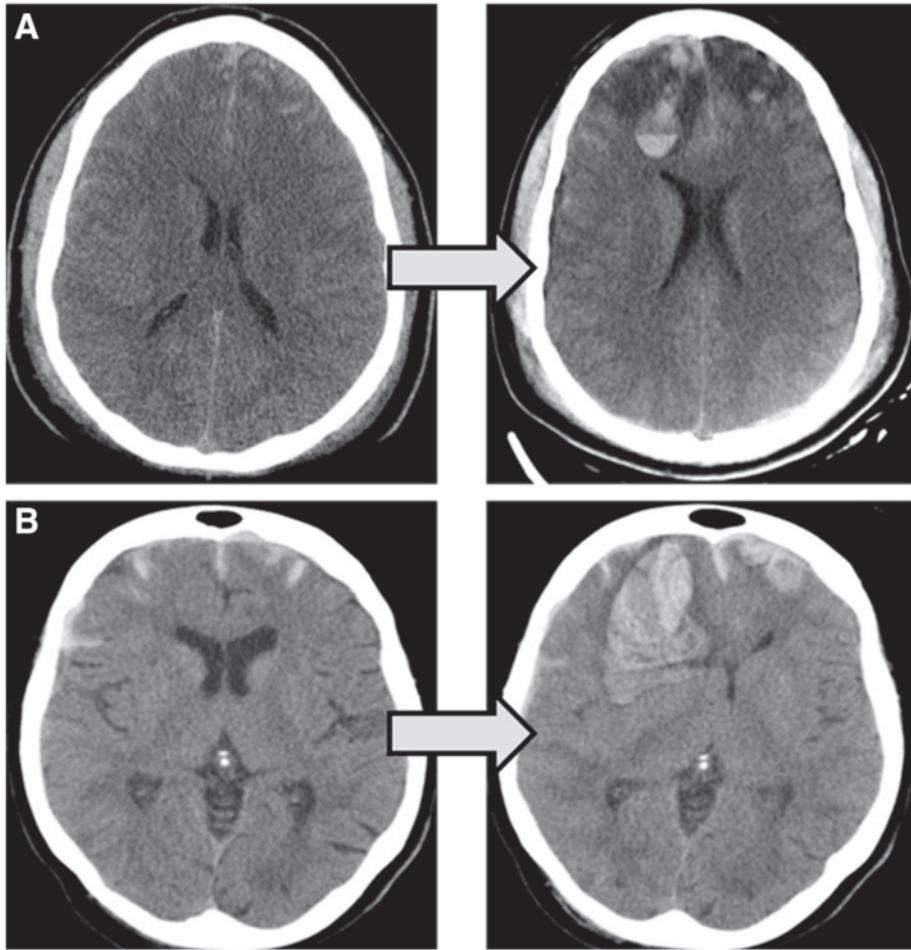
Examples of hemorrhagic progression of contusions in patients a, b on serial brain CT
